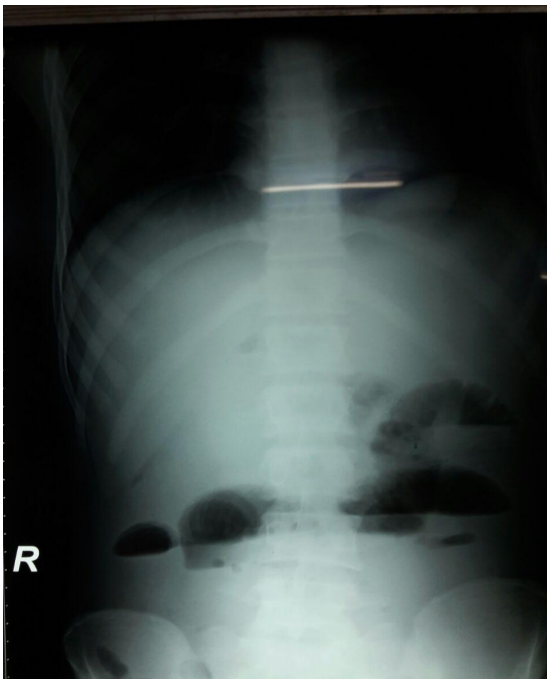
X-Ray abdomen erect showing dilated loop of small bowel
